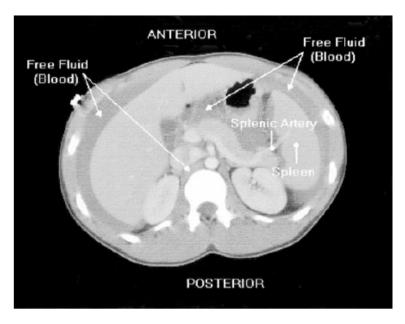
CT scan with contrast - Free Fluid (Blood) in Abdomen
